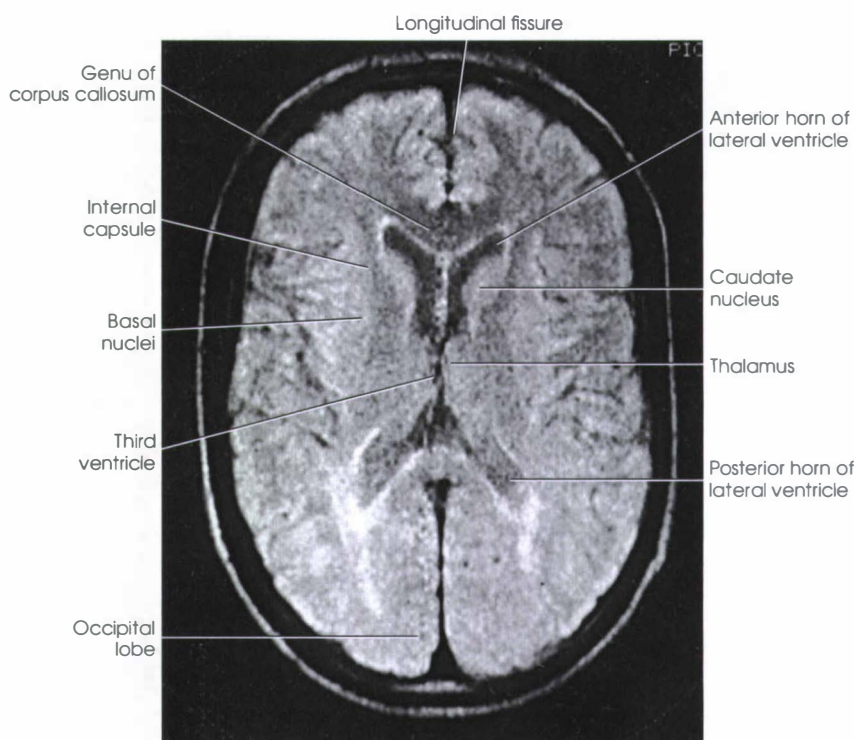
MRI representing the structures located at level B in Fig. 27-1.
